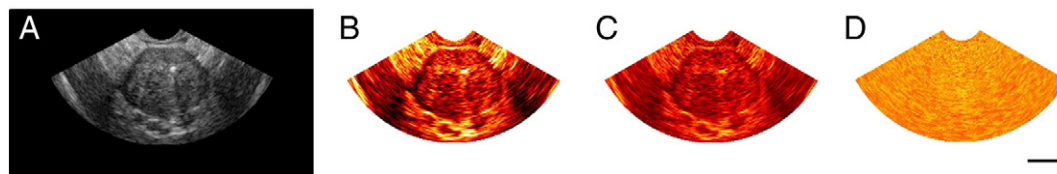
Representative ultrasound image and QUS spectral parametric maps acquired for a PCa patient. (A) Ultrasound B-mode image of prostate and (B-D) the corresponding QUS spectral parametric images of the MBF (B), 0-MHz intercept (C), and spectral slope (D). Scale bar represents ~1 cm.
